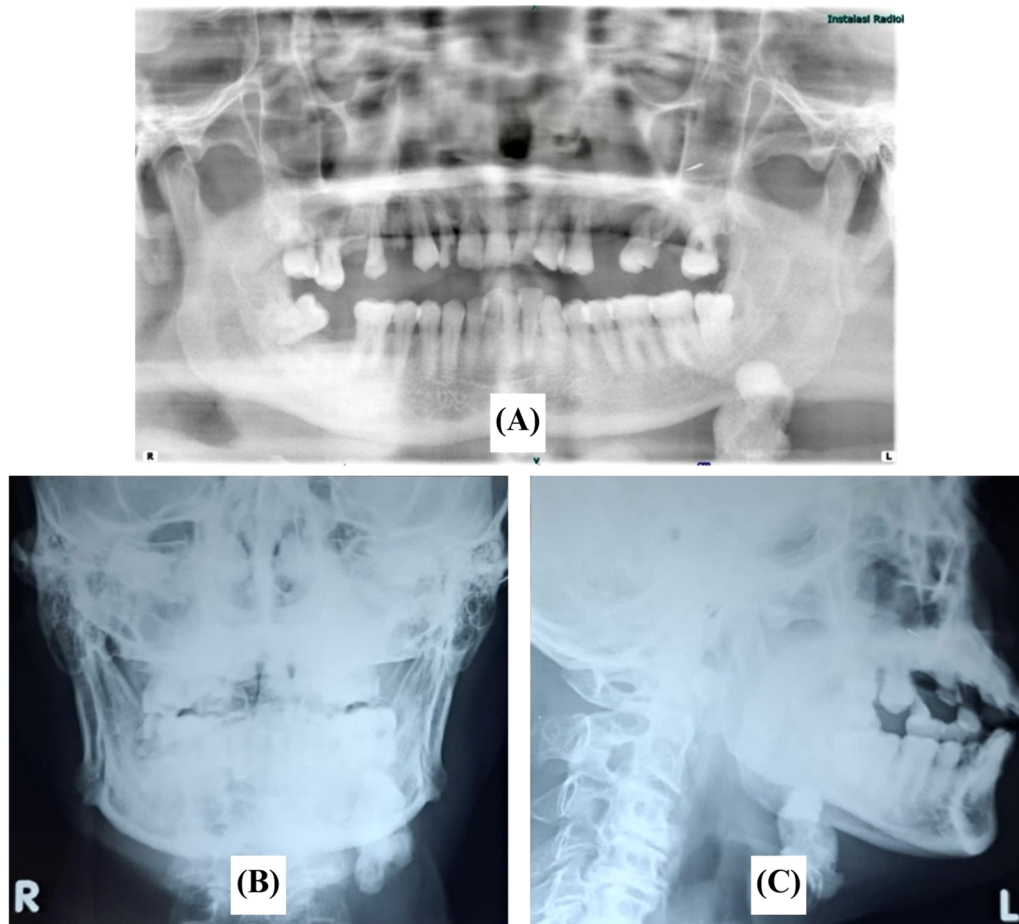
(A) Panoramic radiography, (B) Anteroposterior, and (C) Lateral radiography revealing the radiopaque submandibular gland stone.
